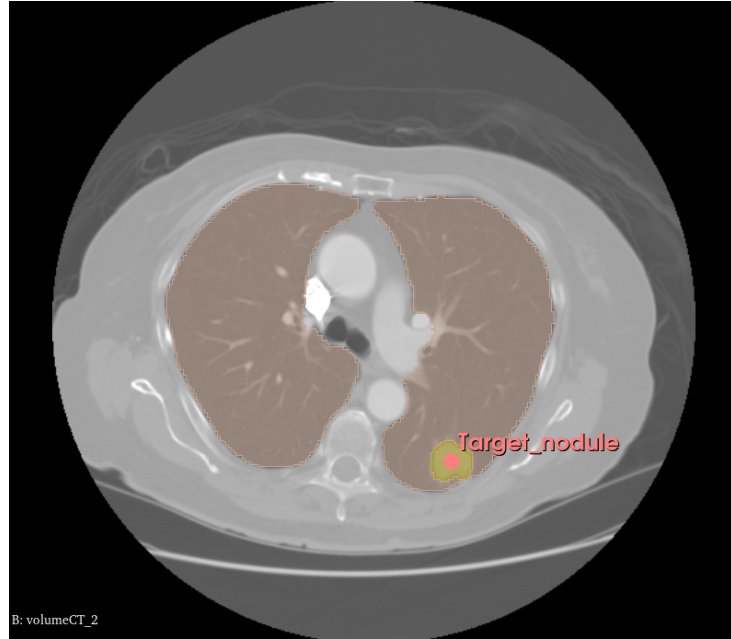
Axial CT view in 3D Slicer showing the manually defined "Target_nodule".
